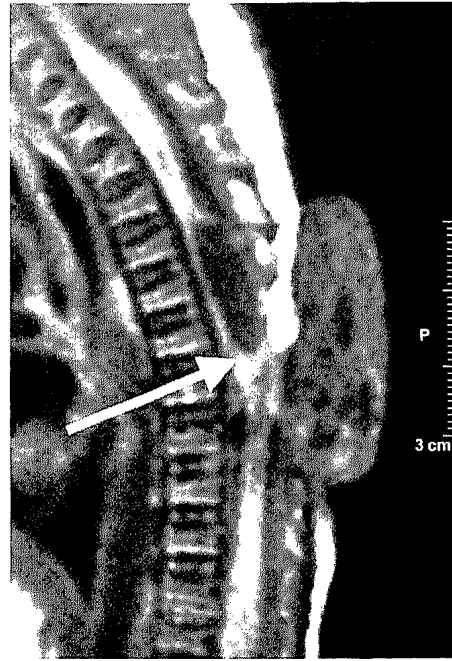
Postpartum MRI scan of the spine showing a cystic lesion at the level Th5–Th6 where the spinal cord has a normal cranio-caudal extension, but at the level of the cele, the cord is tethered posteriorly. Also, at the level of the lesion, a syrinx is visible which is in continuity with the cele and extends in both cranial and caudal directions (arrow).
